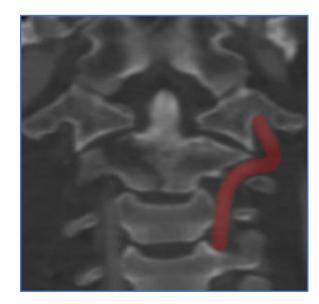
Preoperative native CT scan of C2 with an Anderson Type 3 fracture to evaluate the course of the VA canal (colored).
